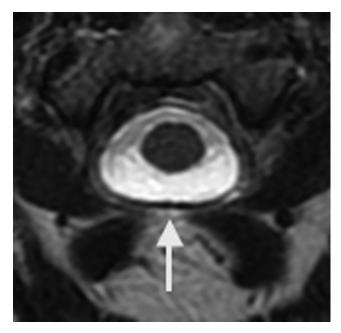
Axial T2 MR image of the cervical spine at the level of C1-C2 shows ectasia of the thecal sac (arrow).
